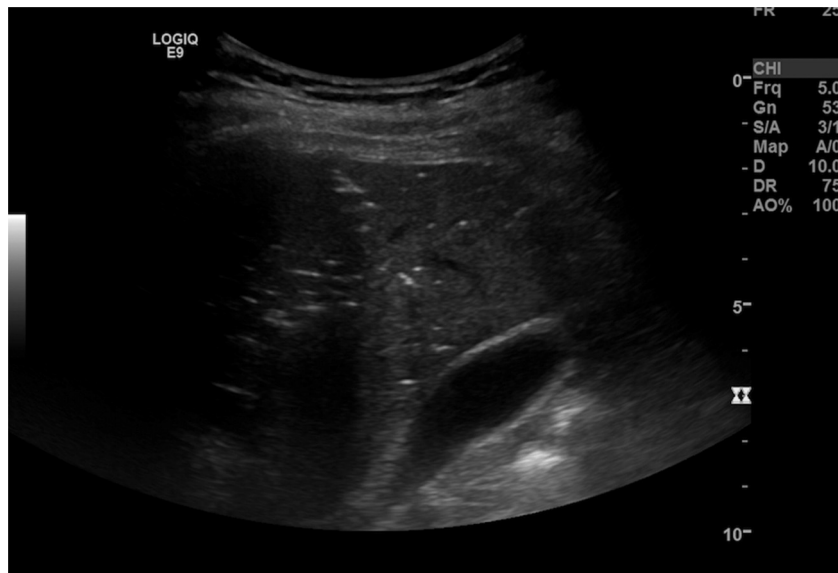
sonography with suspicion of HPVG.
